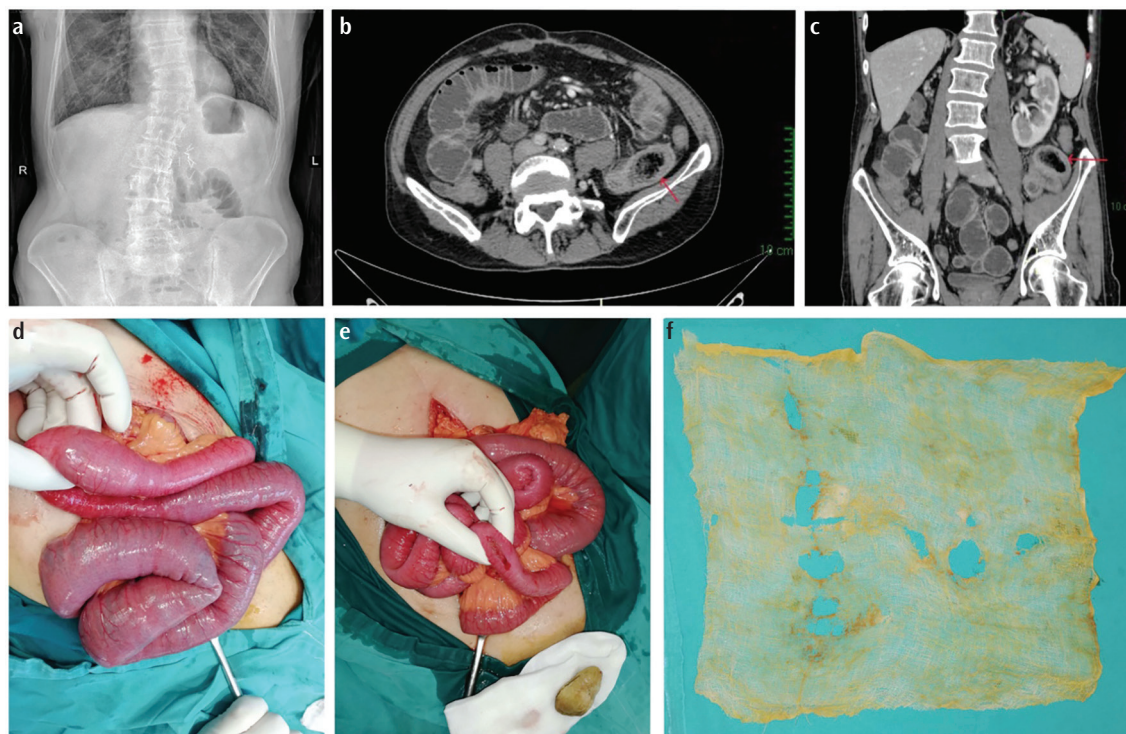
(a) Plain abdominal radiograph. (b) Abdominal CT findings, transverse view. (c) Abdominal CT findings, sagittal view. (d) Intraoperative finding. (e) Longitudinal enterotomy. (f) Surgical gauze 20 × 20 cm. CT, computed tomography.
